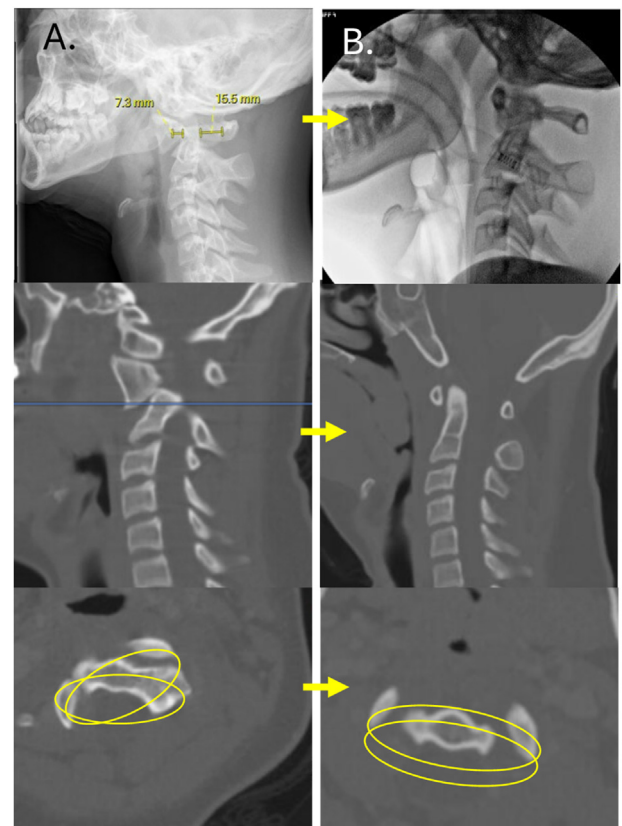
(A) presenting lateral cervical radiograph and CT showing C1-2 subluxation. The patient was treated with inpatient halter traction, which reduced after 5 days. Because of the duration for reduction, the next step was fixation in the halo vest in a reduced position. Overlapping axial plane ovals represent the axial alignment of C1 (seen as the small segments of lateral masses anteriorly and posteriorly in its rotated position) and C2 (more visible, square to the alignment of the CT gantry). (B) Intraoperative upright lateral in halo-vest in a reduced position, confirmed on CT, and represented again with the overlapping ovals now both square to the CT alignment and to one another (with the dens centrally and the C1 lateral masses in their appropriate relationship medially and laterally to the dens). CT, computed tomography.
